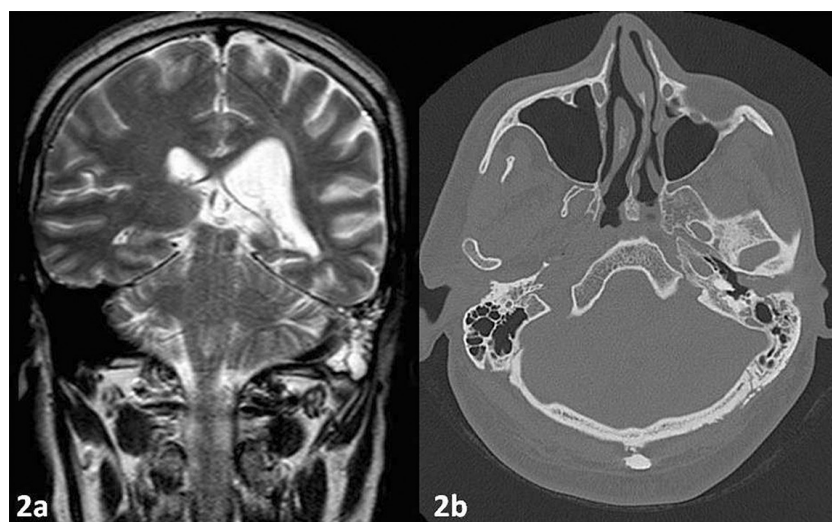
A soft tissue mass at left external auditory canal and middle ear cavity are seen on the temporal MRI (a); a soft tissue mass at external auditory canal extending up to the level of tympanic membrane and causing mild bone destruction at the inferior adjacent bone are observed on the CT scan (b).
